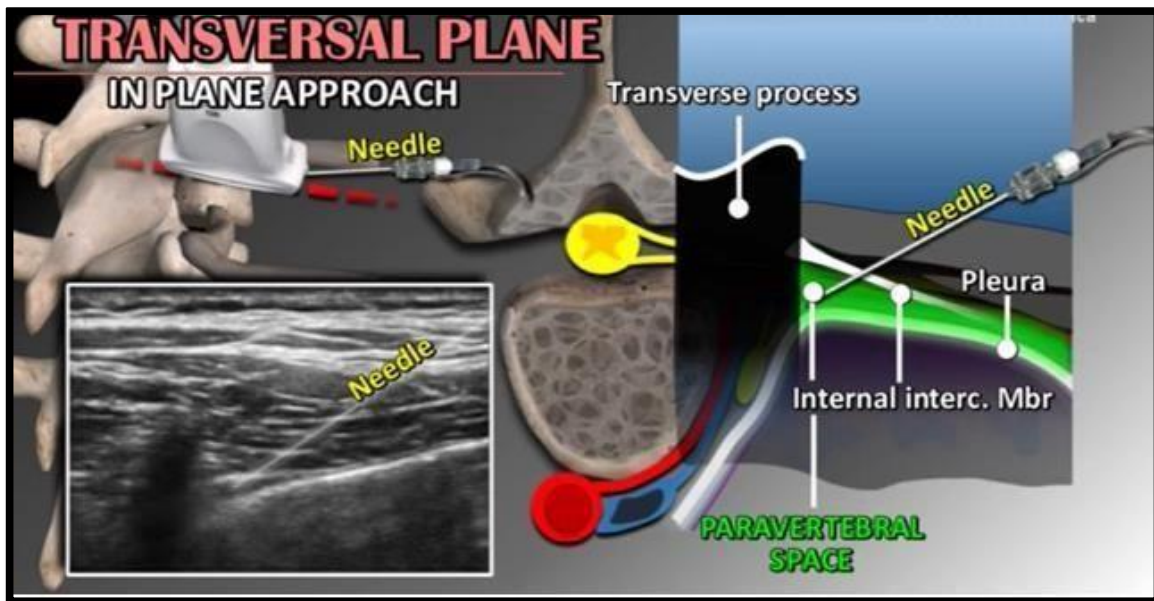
Image displaying the probe orientation, a transverse plane of the expected anatomy at vertebral level T5, as well as a transverse ultrasound image at vertebral level T5 during a paravertebral block. The image was taken from https://www.youtube.com/watch?v=f-gpZPjZ_Tc. Viewed on the 1st of May 2018.
